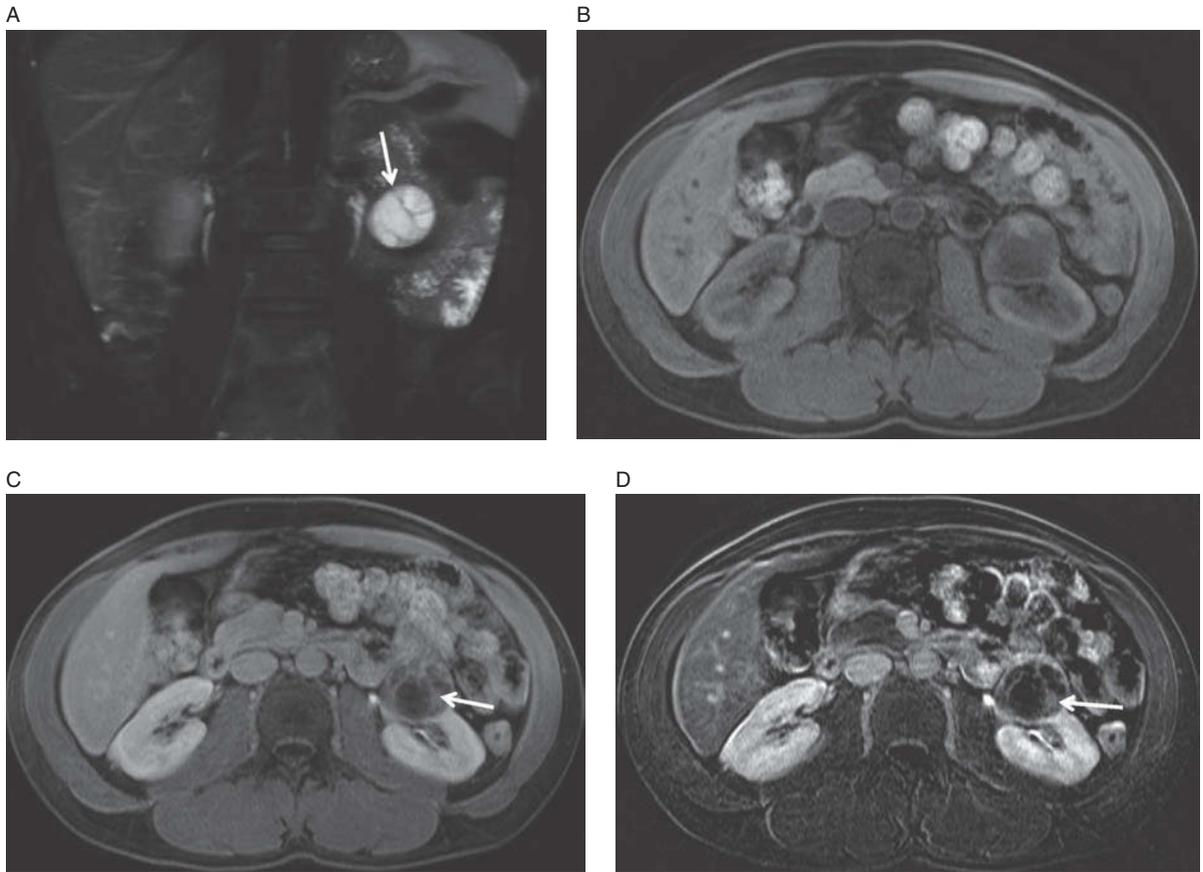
Bosniak III renal lesion (arrow). Coronal T2-weighted image (A) shows cystic lesion with multiple septations. These are too thick. Axial pre-contrast image (B) and post-contrast image (C) demonstrate enhancement of the septations with nodularity (arrow). Subtraction image (D) is provided in case there's any question of whether the enhancement is real.
